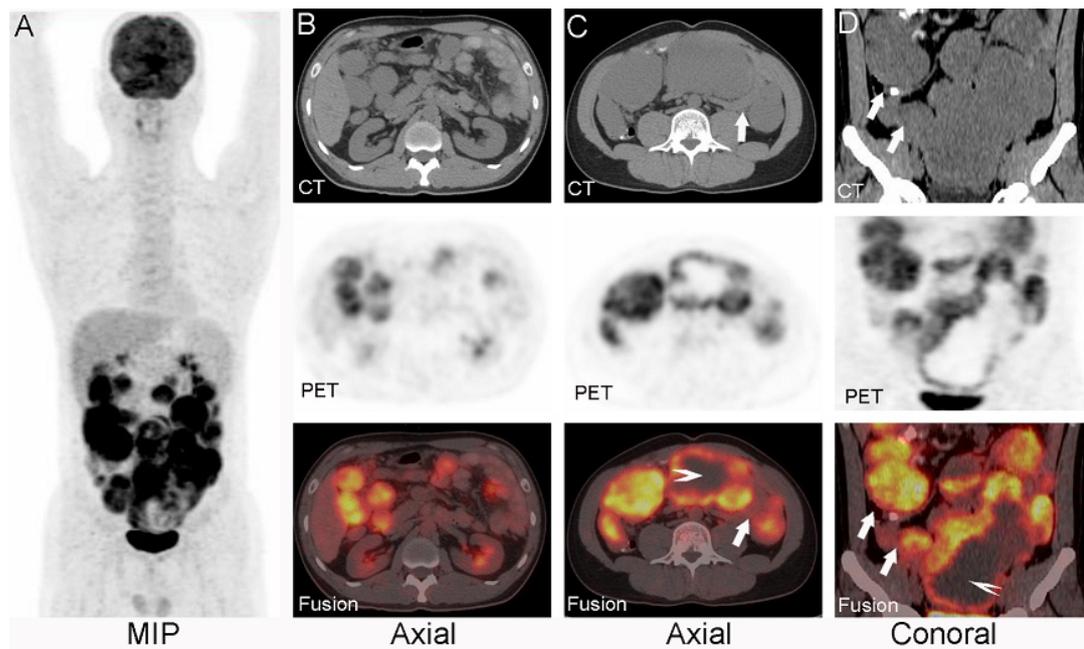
The maximum intensity projection (A) image demonstrated multiple lesions with abnormal ^{18}F -FDG uptake in the abdominopelvic cavity. The transverse images (B) of the abdomen showed multiple space-occupying lesions in the abdominopelvic cavity with an intense ^{18}F -FDG uptake. The transverse images (C) and The coronal images (D) revealed the enormous mass showed peripheral hypermetabolism and internal necrotic area (arrowheads), and the intestinal tract was obviously compressed (arrows).
